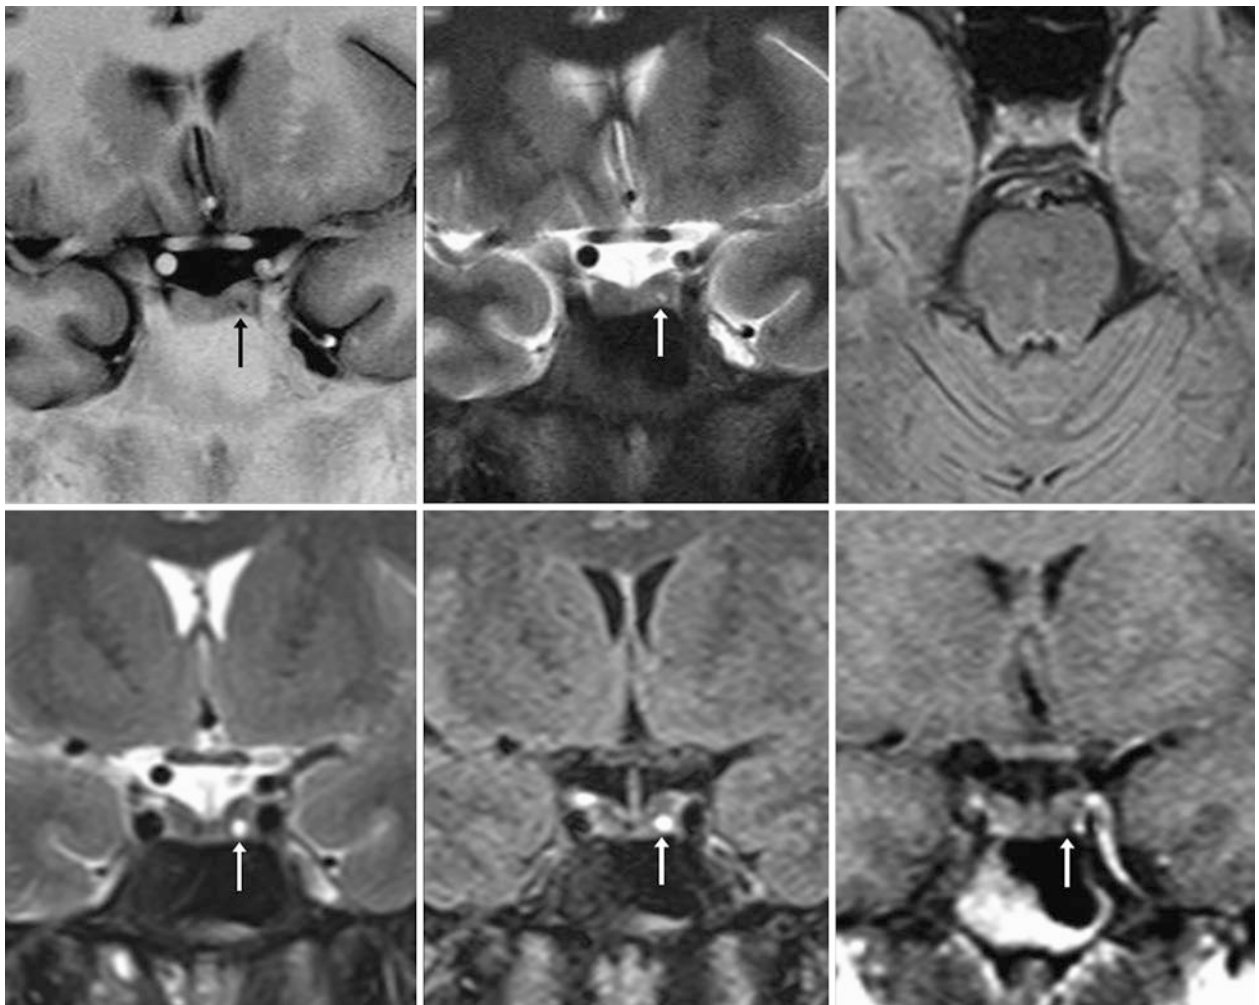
The patient was a 33-year-old female with headaches but no pituitary-related symptoms. A 1.5 T MRI depicted a tiny, 2-mm pars intermedia cyst (RCC) within the left side of the pituitary (arrows) on coronal IR T1WI (top left) and T2WI (top middle) but not seen on axial FLAIR (top right) because of averaging with the normal gland. On a 1.5 T MRI 9 years later, there was no change on coronal T2WI (bottom left), FLAIR (bottom middle), or postcontrast T1WI (bottom right)
